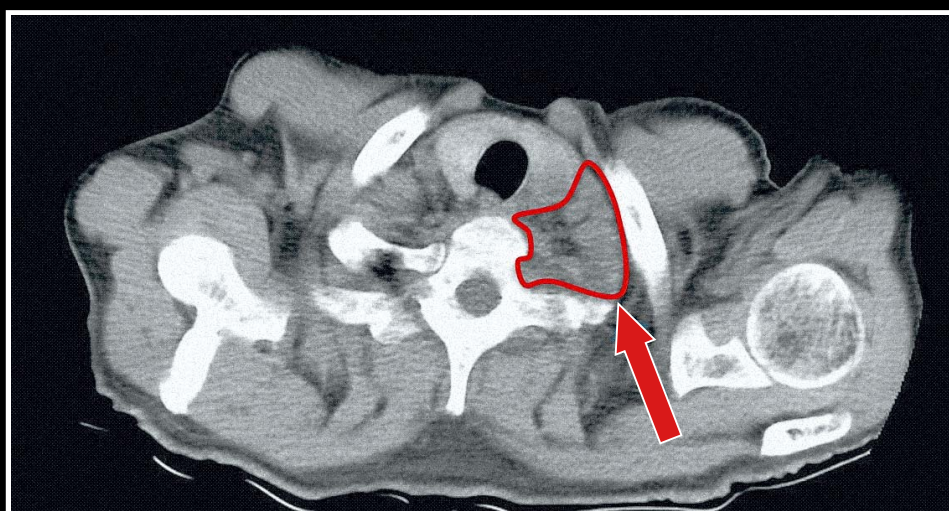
Native CT scan that shows a macronodule with non-homogeneous structure due to round hypodensities (arrow), with axial dimensions of 32/30 mm and a cranio-caudal dimension of 33 mm, projected posteriorly and inferiorly to the left thyroid lobe.
